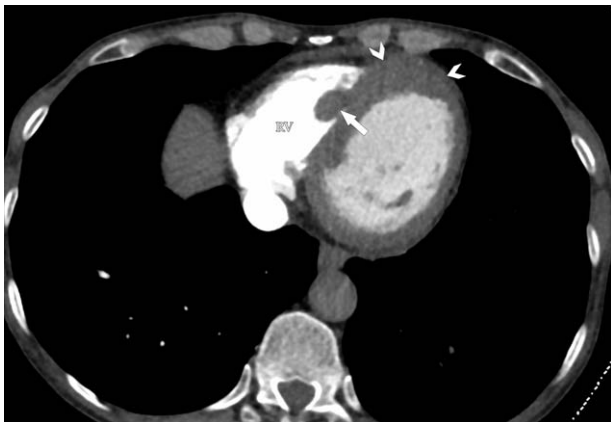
Axial contrast-enhanced CT (arterial phase) at the level of the ventricular chambers shows a hypodense filling defect (arrow), within the right ventricle (RV), consistent with an intracavitary thrombus, along with a localized thickening (arrowheads) of the apical myocardium. CT = computed tomography.
